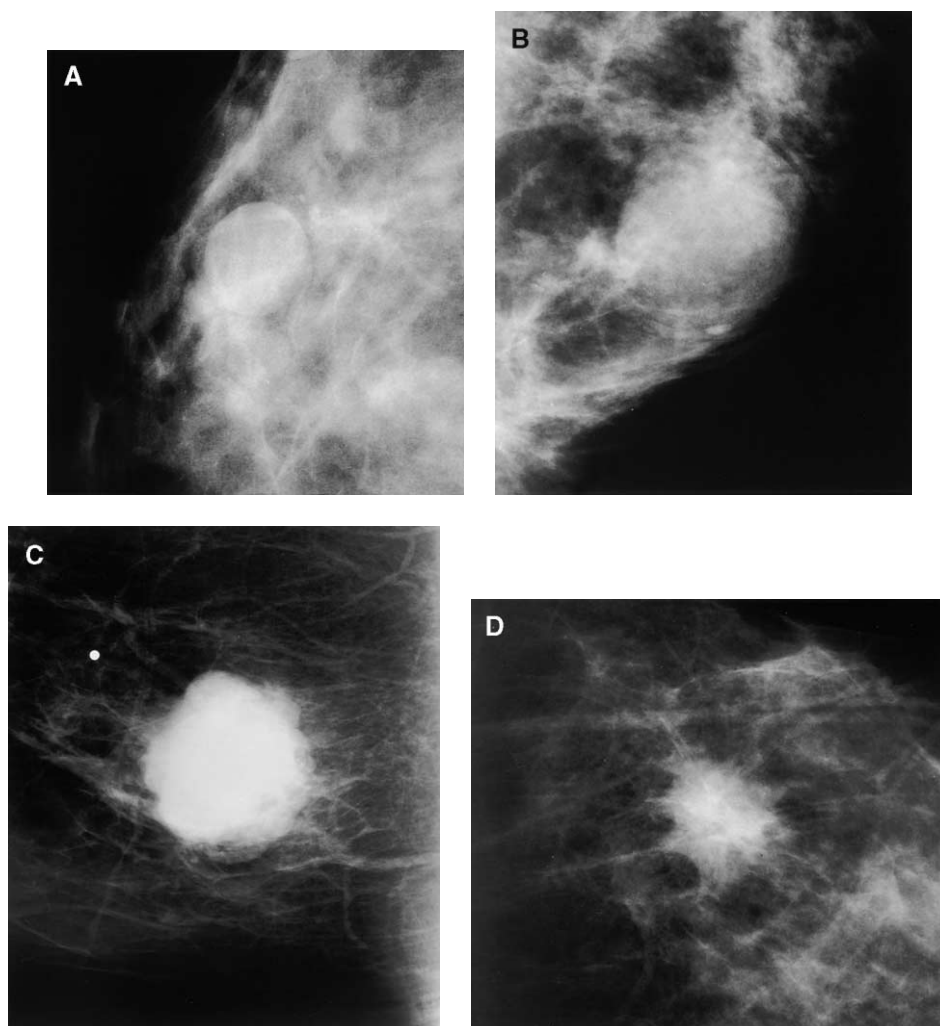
Mass margin characteristics as defined by the BI-RADS lexicon. (A) Circumscribed mass, shown to be a simple cyst at sonography. (B) Partially obscured mass; sonography showed as simple cyst. (C) Microlobulated mass corresponding to palpable lump denoted by radiopaque skin marker; biopsy showed infiltrating ductal carcinoma and ductal carcinoma in situ (DCIS). (D) Spiculated mass; biopsy showed infiltrating ductal carcinoma and DCIS.
